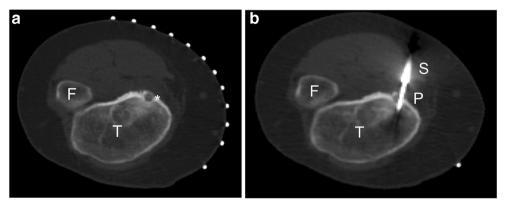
a 23-year-old girl presenting with an osteoid osteoma (*) of the tibia (T) depicted on this axial planning CT scan. F fibula. b 23-year-old girl presenting with an osteoid osteoma of the tibia. Axial CT image
